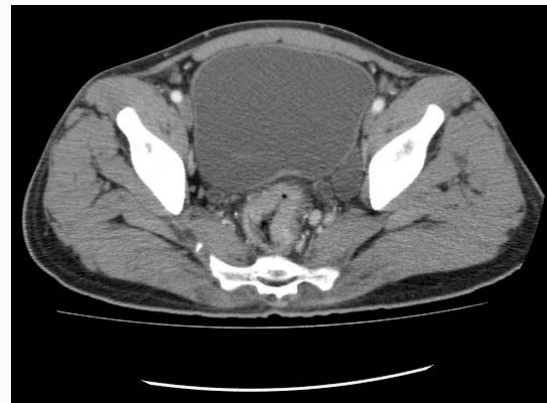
Pretreatment PET/CT Scan showing the avid rectal cancer.
